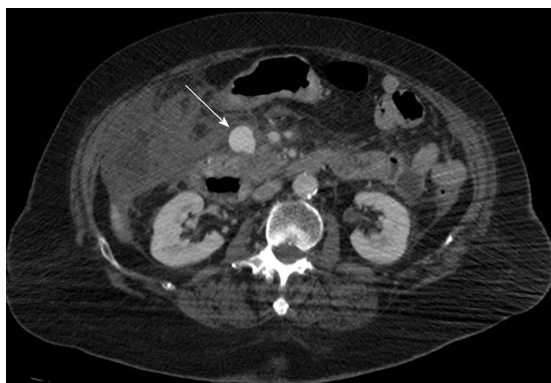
Axial contrast-enhanced computed tomography showing pancreatico-duodenal artery pseudoaneurysm (arrow) before the treatment.
